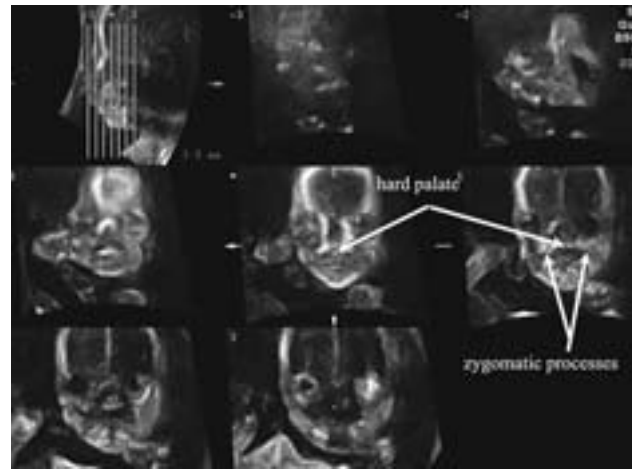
Tomographic Ultrasound Imaging (TUI) of the secondary palate in the coronal plane.
